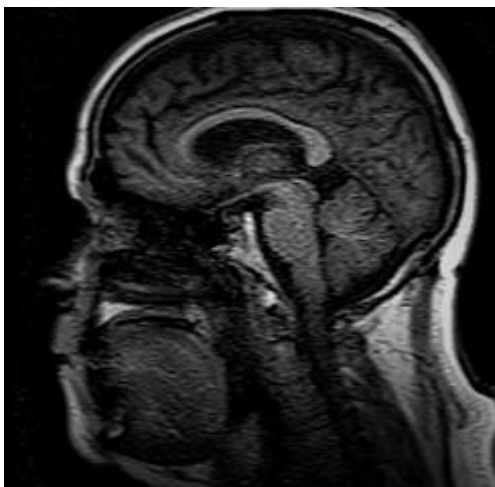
Brain Magnetic resonance imaging (MRI) showing bilateral signal anomalies of the internal temporal region and hippocampal left lesions.
